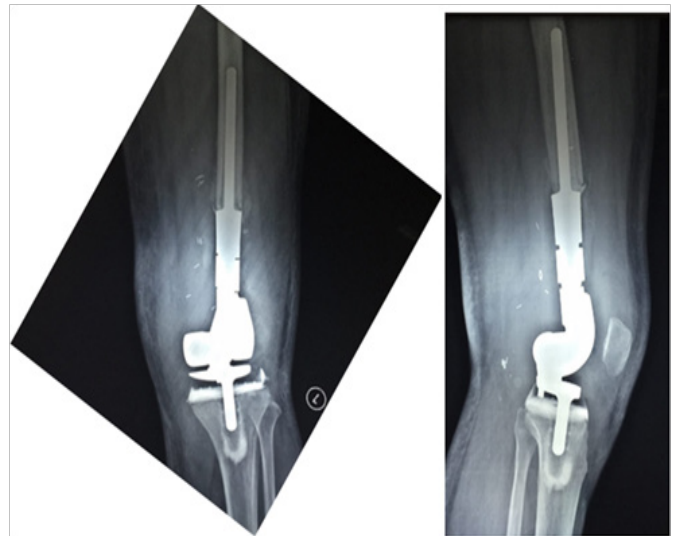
Initial radiograph of Left Knee AP and Lateral view showed that the prosthesis was held in position with suspected periprosthetic effusion.
